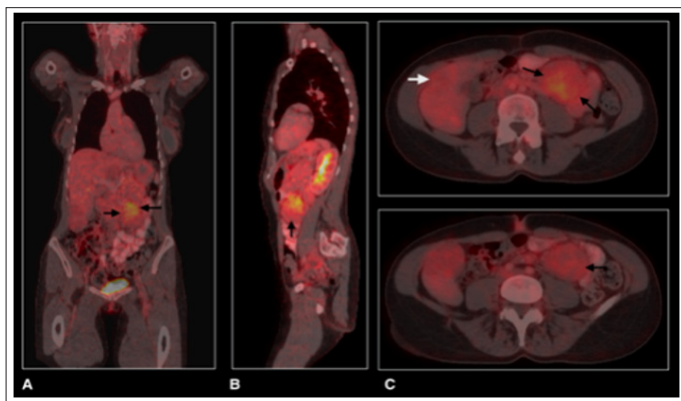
PET-CT. A) Coronal, B) Sagittal, C) Axial views Showing Mesenteric Lesion (Black Arrows) with 4.6 SUV and Liver Lesions without FDG Uptake (White Arrow)
